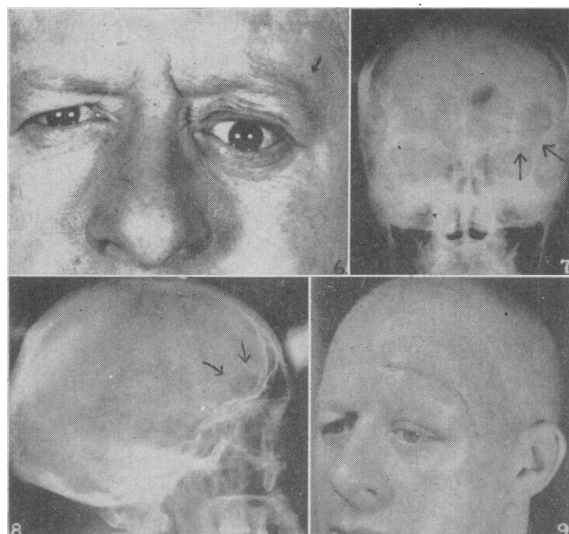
(Case 2).—Preoperatively. Figs. 7 and 8. (Case 2).—X-ray views of lesion. Fig. 9. (Case 2).—Postoperatively.
